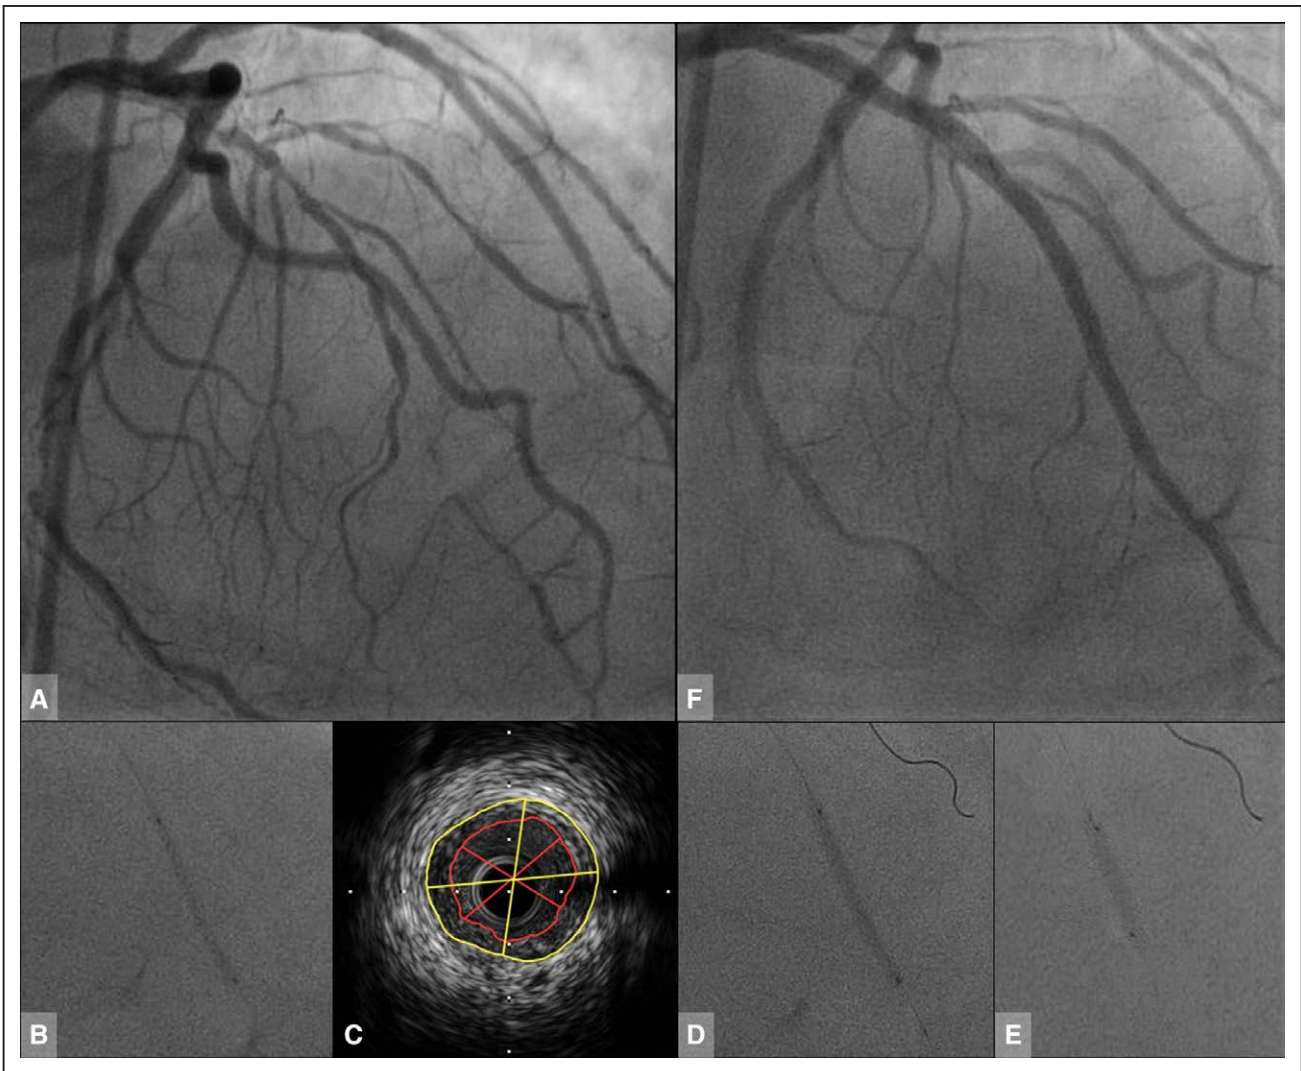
Representative case of BVS implantation for LAD CTO. A, Angiography before PCI of LAD CTO; B) predilatation with 2.0 mm semicompliant balloon for CTO lesion; C) IVUS evaluation before BVS implantation; D) BVS (2.5/28 mm) implantation for CTO lesion; E) postdilatation with 3.0 mm noncompliant balloon after 2.5 mm BVS implantation for CTO lesion according to the IVUS evaluation; and F) final angiography after revascularization with BVS. BVS indicates bioresorbable vascular scaffold; CTO, chronic total occlusion; IVUS, intravascular ultrasound; LAD, left anterior descending artery; and PCI, percutaneous coronary intervention.
